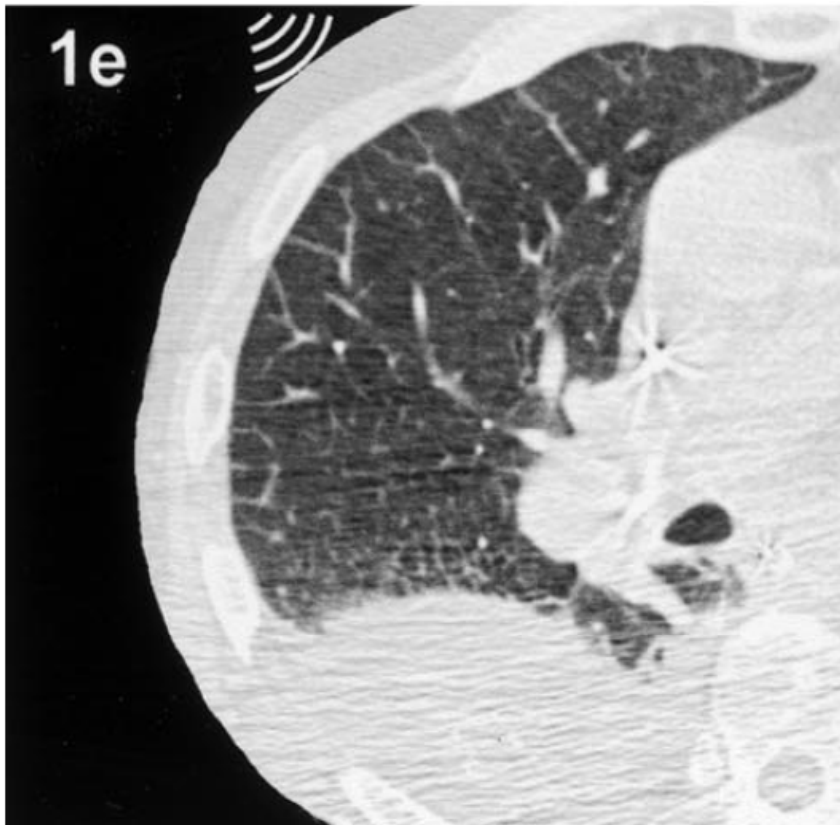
Different chest sonography patterns. *ULCs*, ultrasound lung comets.
